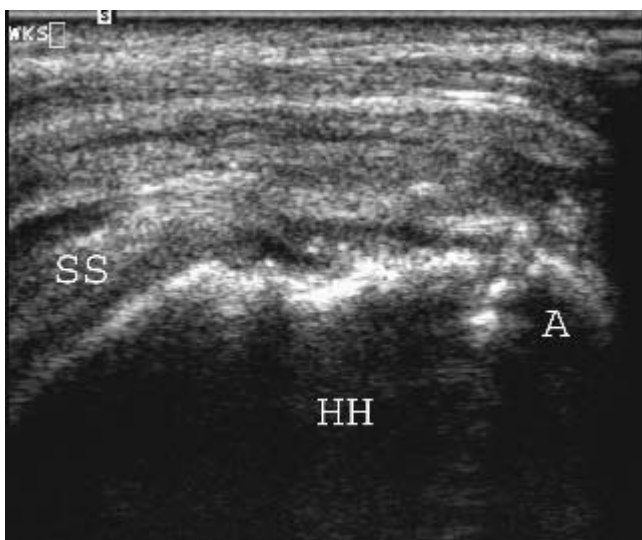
Postoperative ultrasound demonstrating an intact repair of the supraspinatus tendon in which the tendon (SS) can be seen attaching directly to the humeral head (HH). Note the presence of a metallic suture anchor (A).
